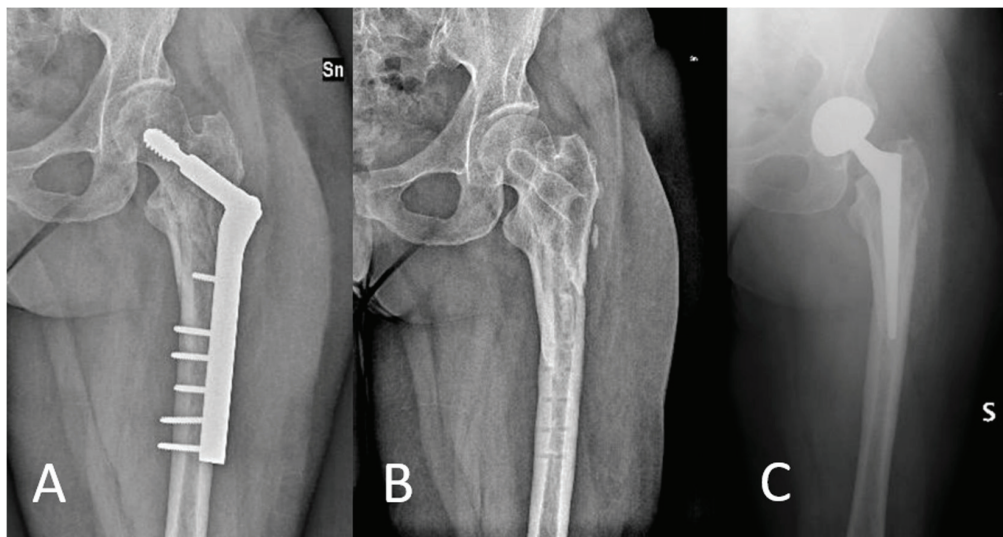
Patient underwent removal of synthesis devices and total hip replacement ((A): X-ray after treatment with DHS; (B): X-ray after removal of synthesis devices; (C): X-ray after total hip replacement surgery).
